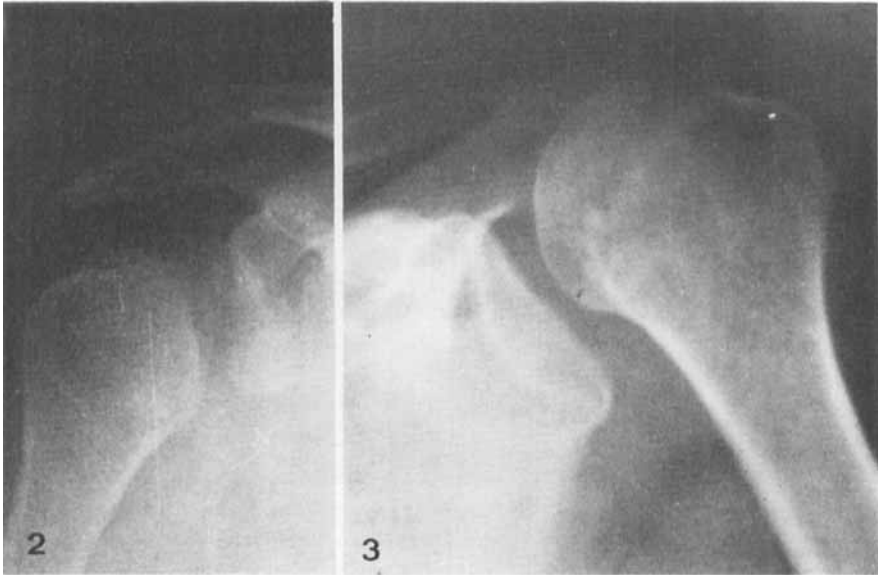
See text on suggestive signs seen on anteroposterior roentgenograms.
